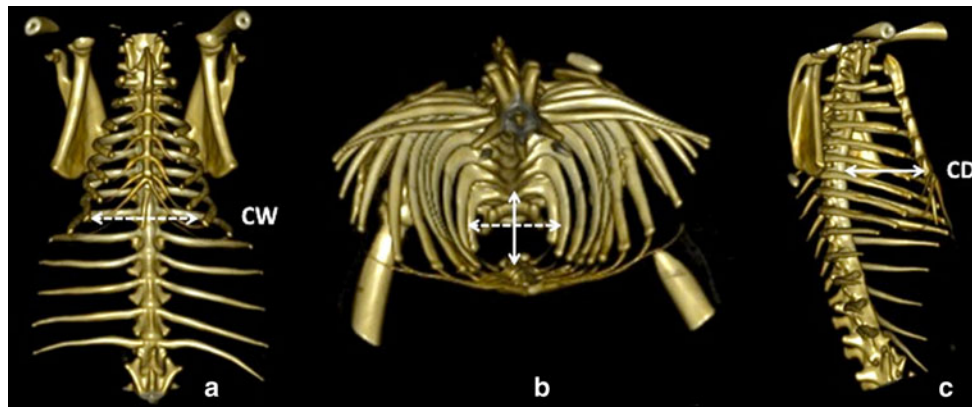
Computed tomography scan with three dimensional reconstruction of the chest. Frontal view (a), top view (b) and lateral view (c) of the thoracic cage. CW chest width, CD chest depth
